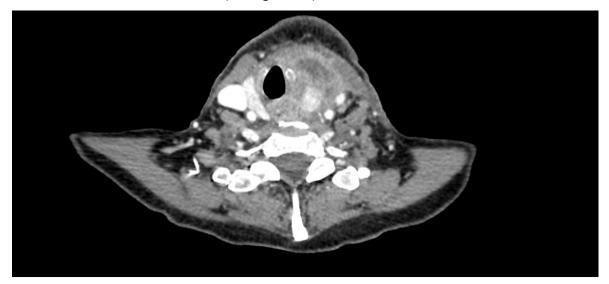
Axial CT scan demonstrating large hypopharyngeal cancer in left pyriform fossa. Image source: Poole Hospital Foundation Trust.
